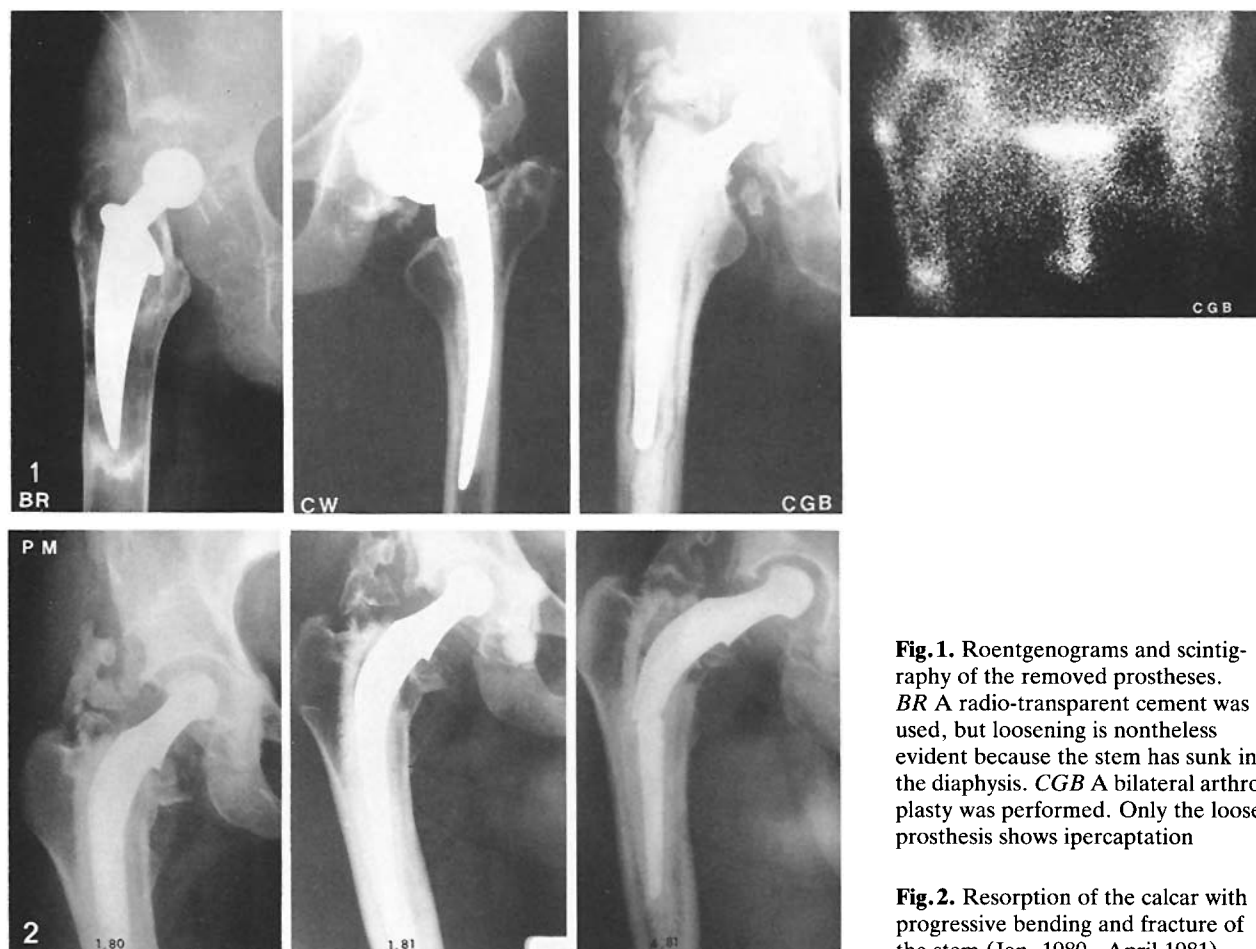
Roentgenograms and scintigraphy of the removed prostheses. *BR* A radio-transparent cement was used, but loosening is nonetheless evident because the stem has sunk in the diaphysis. *CGB* A bilateral arthroplasty was performed. Only the loose prosthesis shows ipercaptation
